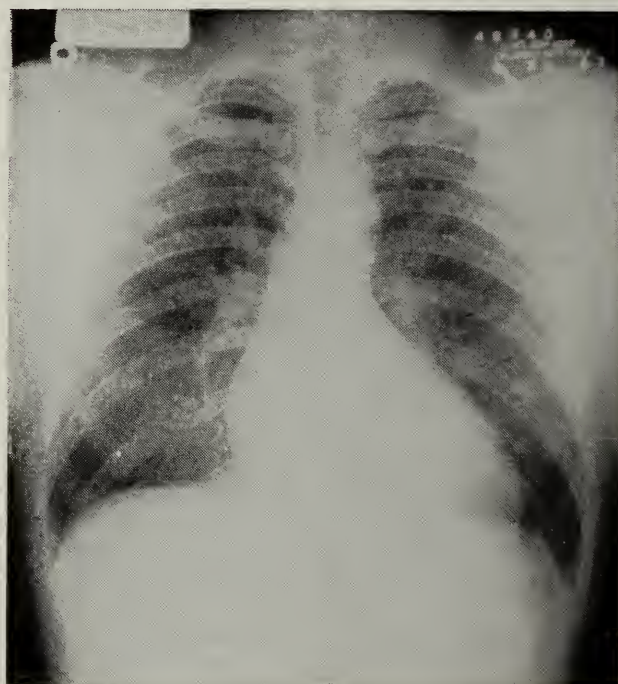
Roentgenogram of chest. No further changes were noted on subsequent examinations.
